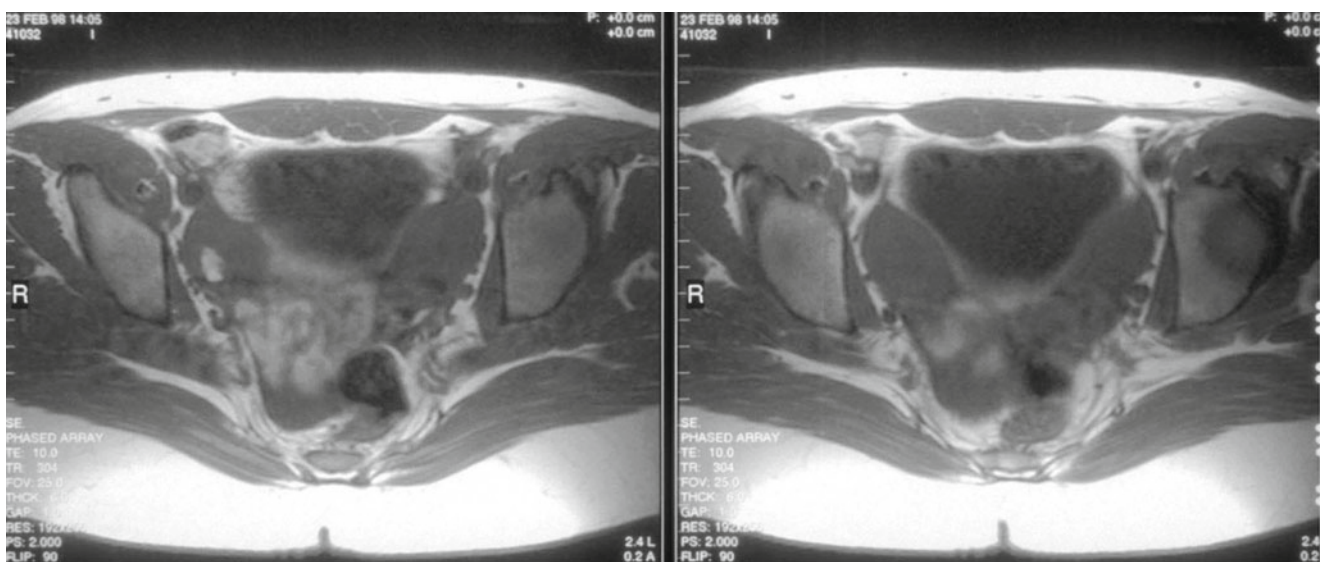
Magnetic resonance image of functioning rudimentary bulbs (reproduced with permission from Attaran M, Gidwan G, Ross J. In: Hurd WW, Falcone T, eds. *Clinical reproductive medicine and surgery*. St. Louis, MO: Mosby/Elsevier; 2007)
